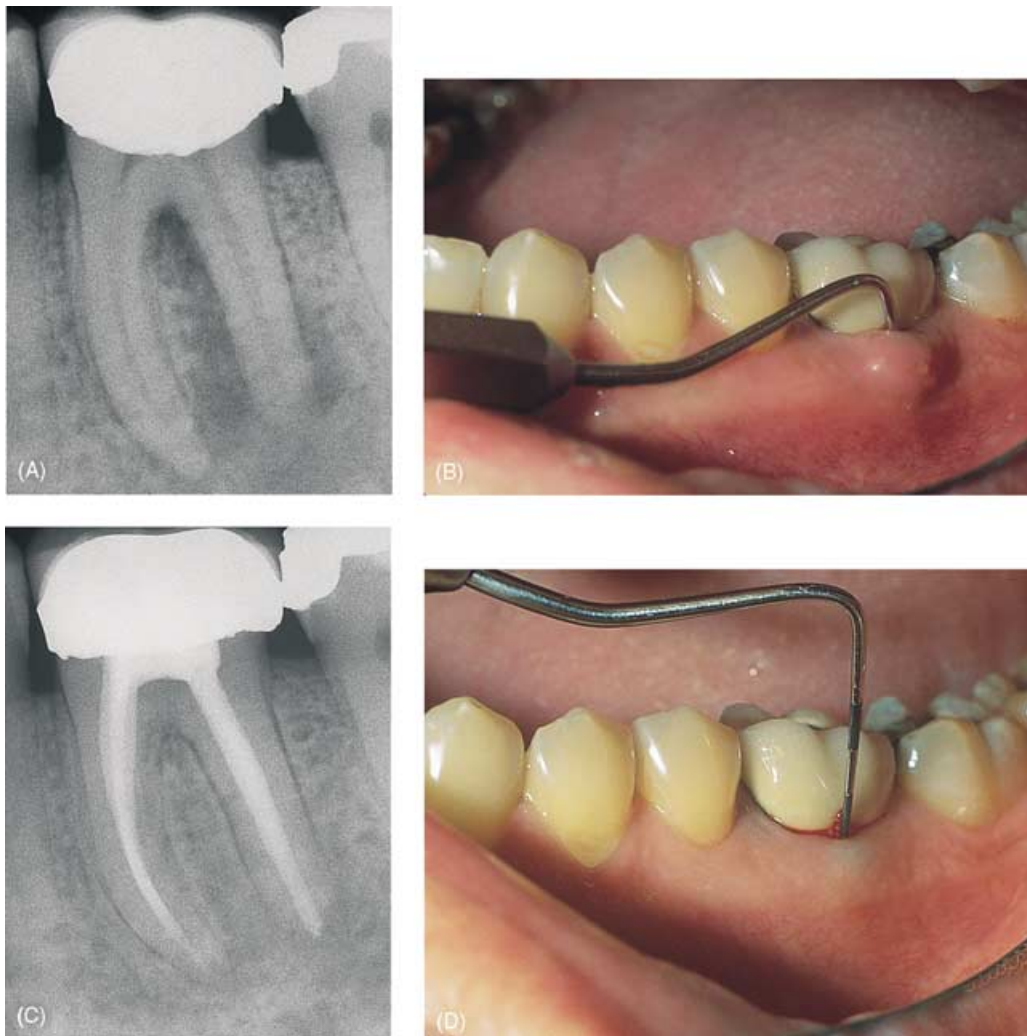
Primary endodontic disease in a mandibular first molar with a necrotic pulp. (A) Preoperative radiograph showing large periradicular radiolucency associated with the distal root and furcal lucency. (B) Clinically, a deep narrow buccal periodontal defect can be probed. Note
